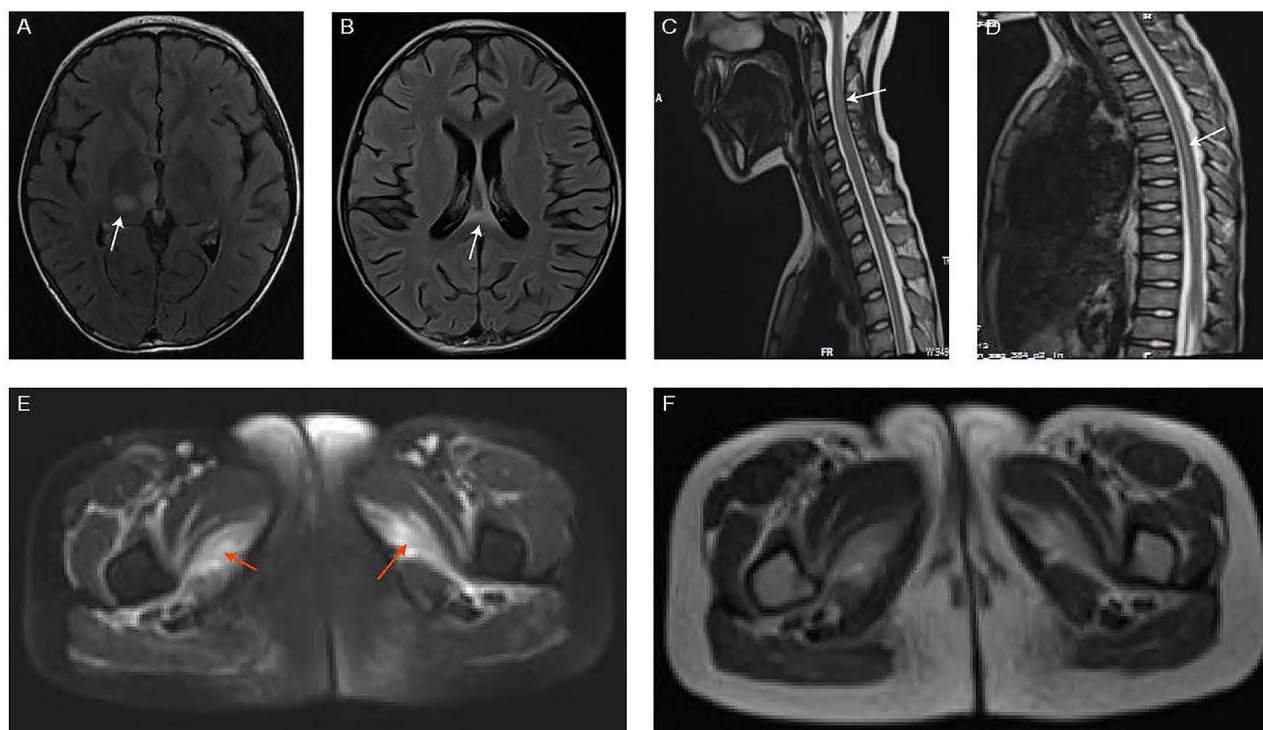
MRI of the patient. (A and B) Brain MRI of the patient, T2 fluid attenuated inversion recovery (FLAIR) sequence. (A) Lesions on the right thalamus (white arrow). (B) Lesions on the corpus callosum (white arrow). (C and D) T2 sequence of spine MRI of the patient, showing longitudinally extensive lesions (white arrows). (E and F) Thighs MRI of the patient, demonstrating bilateral abnormal signals (red arrows). (E) Short tau inversion recovery sequence. (F) T2 sequence.
